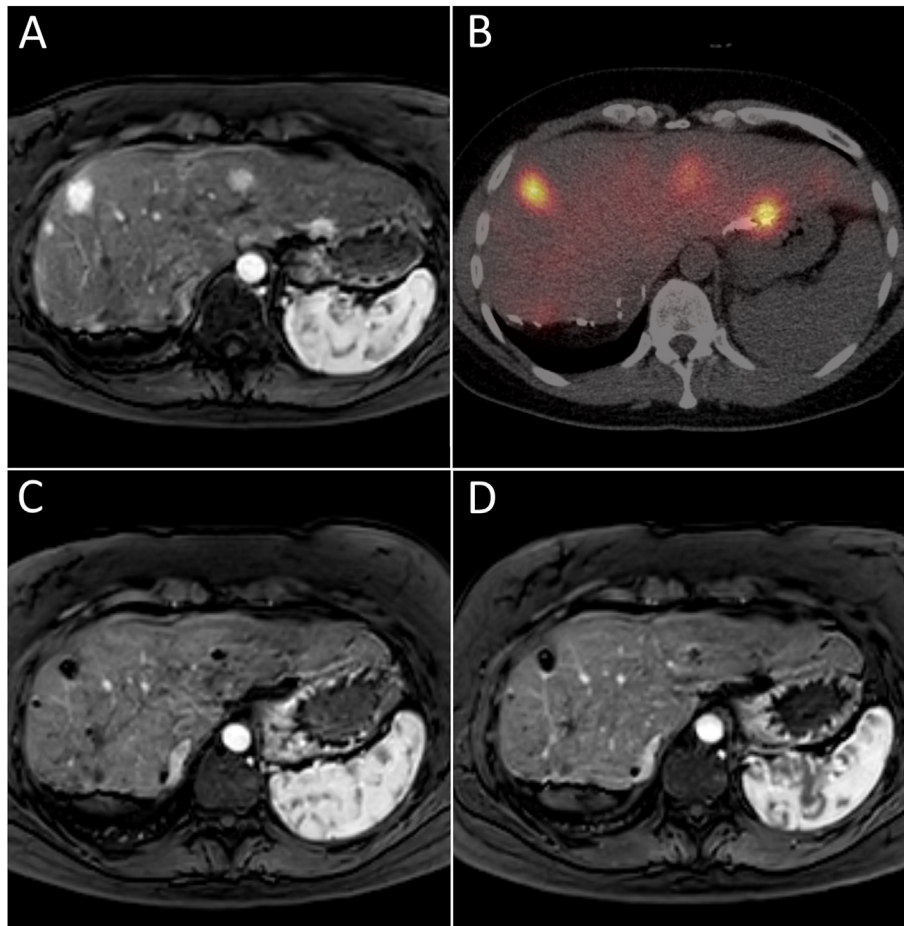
An example of a patient with a multifocal recurrent hepatocellular carcinoma (HCC), treated with ^{166}Ho -microspheres. (A) Magnetic resonance imaging (MRI) at baseline showing multiple hypervascular lesions in the remnant liver after right-sided hemi-hepatectomy, the largest in segment IV. (B) Post-treatment ^{166}Ho single photon emission computed tomography/computed tomography (SPECT/CT), showing good targeting of the HCC lesions. (C) MRI 1 day after treatment demonstrating depositions of microspheres inside the tumour in black. (D) MRI at 3 months post-treatment, showing avascular lesions.
